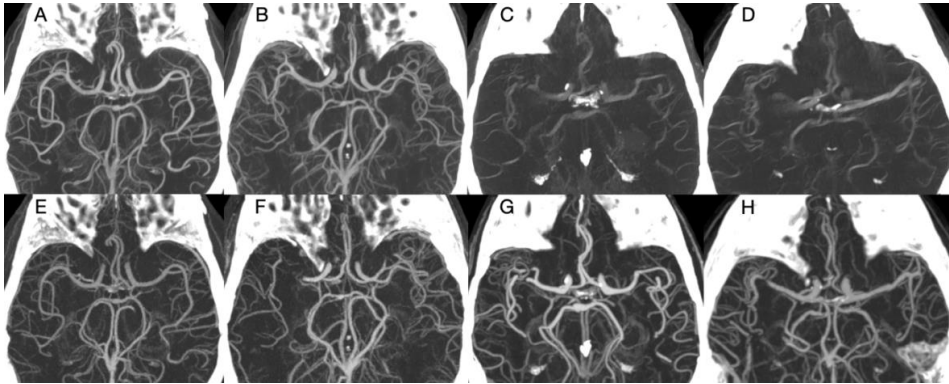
DL-CBCTA 70 keV images (top row) and CTA (bottom row) with MIP 35 mm slice thickness. A and B shows acceptable quality DL-CBCTA scans, while C and D shows typical scans in the dataset affected by motion artifacts. Bottom row (E to H) shows corresponding patient CTA. Note that images F, G and H show a right sided middle cerebral artery occlusion, which have been extracted at the time for DL-CBCTA imaging. Only the arteries in the unaffected hemisphere were evaluated. DL-CBCTA = Dual-layer cone-beam CT angiography; CTA = CT angiography; MIP = Maximum Intensity Projection
